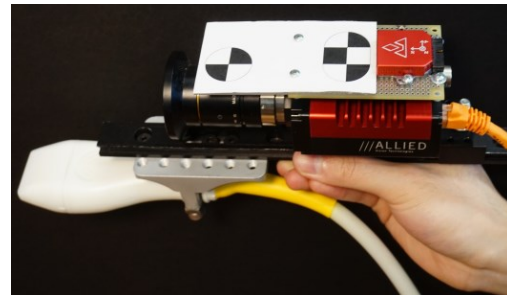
Ultrasound probe with mounting bracket and slide rail for the camera and INS.
